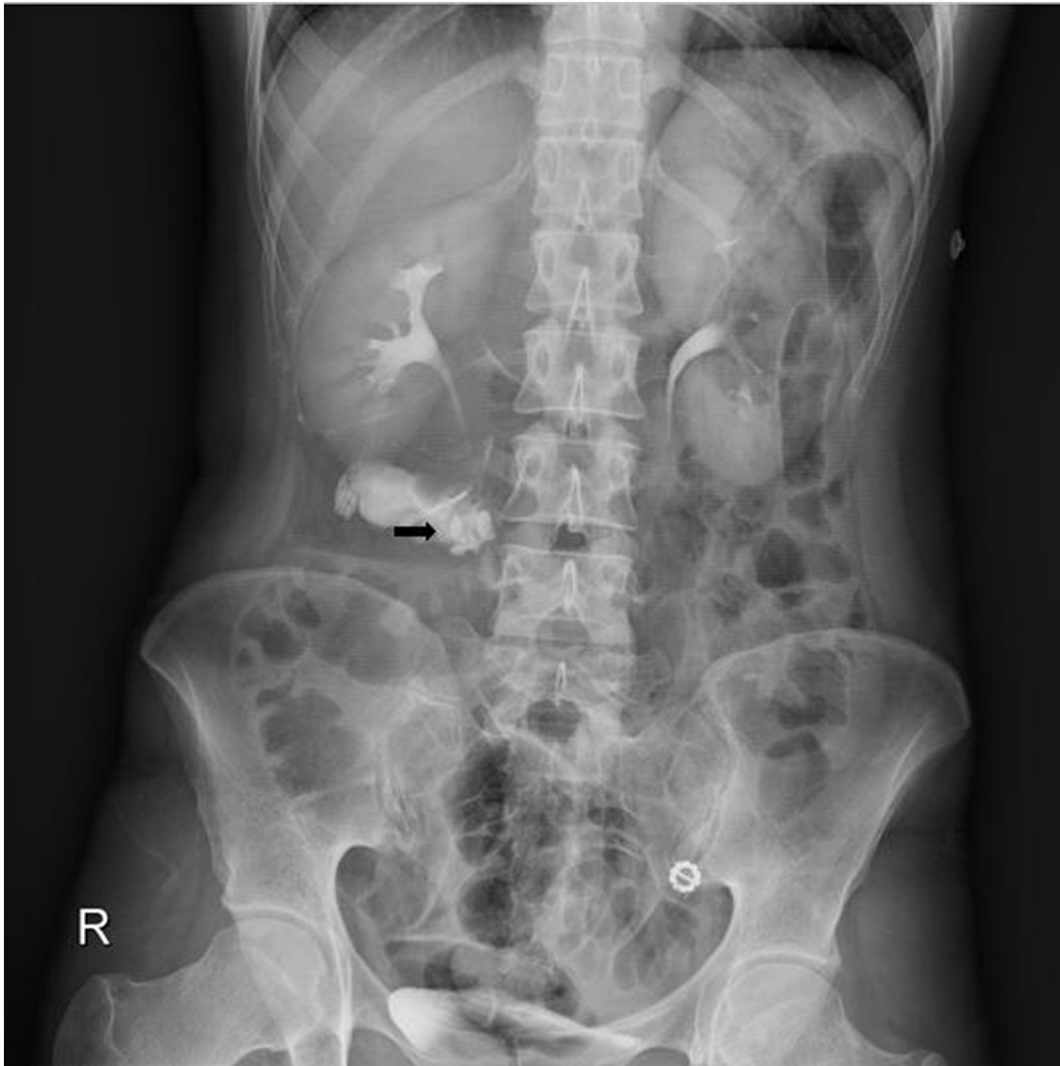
Simple abdominal X-ray after computed tomography. Showing leakage of contrast around the right ureter (black arrow).
